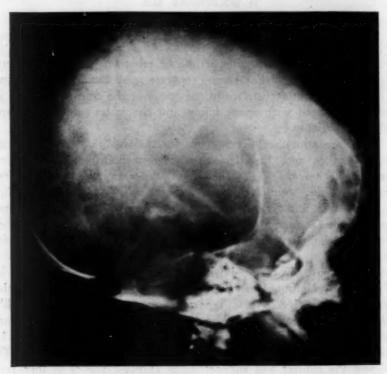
Postmortem roentgenogram showing pronounced lacunar formation of the frontal bones, with hydrocephalus.
